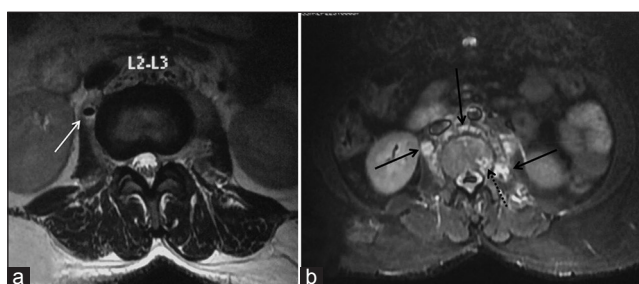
(a) Axial T2-weighted and (b) short tau inversion recovery (STIR) magnetic resonance images showing small air focus in right upper psoas muscle (white arrow) in axial T2-weighted image and multiple small collections in pre and bilateral paravertebral locations (black arrows) with L3 vertebral involvement (dotted black arrow) in STIR images
